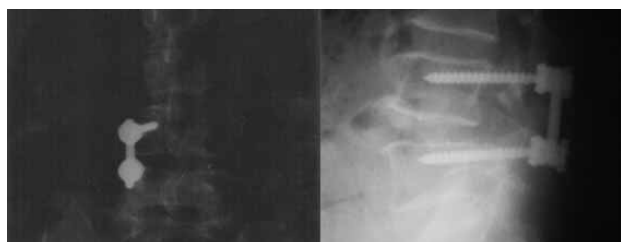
X-ray taken after the unilateral TLIF procedure.
